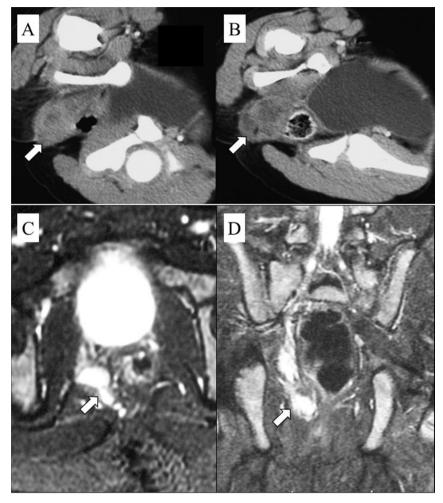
Computed tomography and magnetic resonance imaging findings. A, B: An abscess with a diameter of approximately 4 cm was observed in the posterior rectum. It led to the right anus at the bottom and the right ischiorectal fossa during initial treatment. C: Axial view. A cord-like cystic mass with multiple cavities squeezing the rectum from the right rear side was confirmed. D: Coronal view. A cord-like cystic mass reached the coccygeus deeply on the cranial side during the second treatment. White arrow: abscess.
